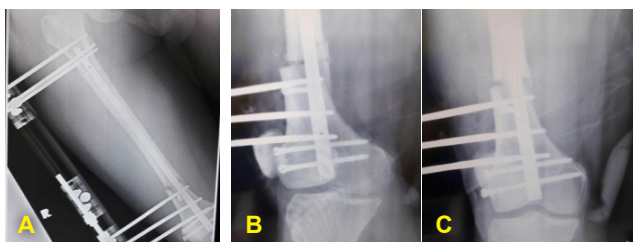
A) Post-operative x-ray anterior posterior (AP) view showing correction of valgus deformity using LRS monorail external fixator with subsequent lengthening of the bone on nail B) lateral view of distal femur showing the osteotomy site and correction of valgus deformity
